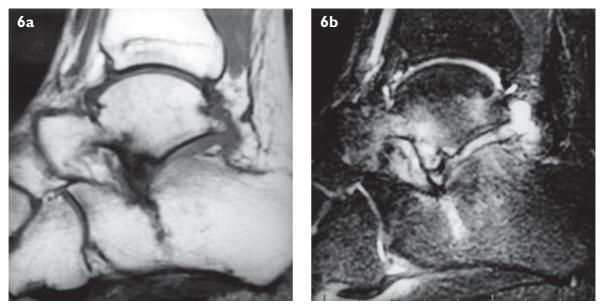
35-year-old man with fractures of the talus and calcaneum. Sagittal (a) TI-weighted and (b) T2-weighted MR images show an oblique fracture in the talus and a vertical fracture in the mid-calcaneum. Both fractures involve the subtalar joint. There is patchy bone oedema in both bones, with ankle and subtalar joint effusions.
